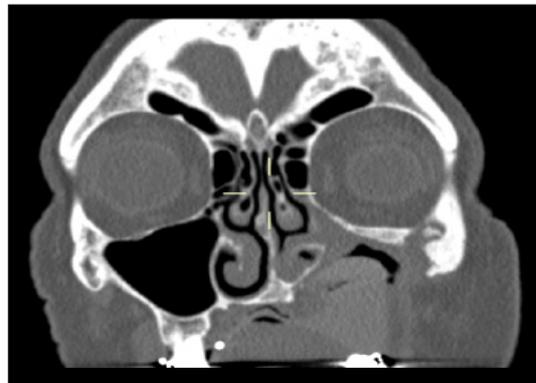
CT scan showing obliteration of the left maxilla, left maxillary sinus and extension left orbital floor.
